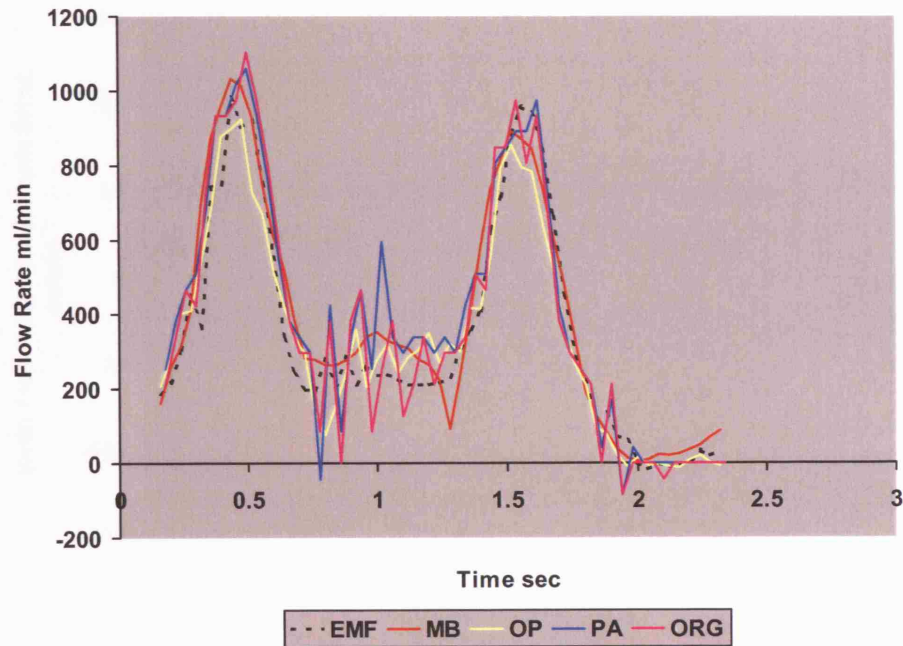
Moving silicone tubing experiments: An example of x-ray calculated and EMF waveforms. The mean EMF flow rate was 347 ml/min.
